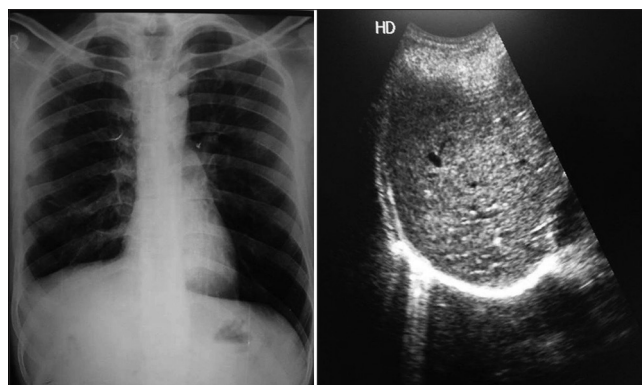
Follow-up Chest X-ray and USG of the abdomen after 3 months demonstrating complete radiological clearance of the pleural effusion and biloma(s), respectively
